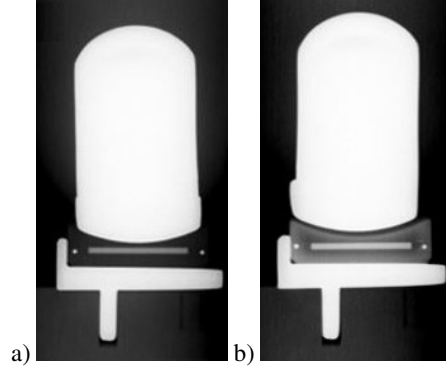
Standard radiographs taken of a) a conventional polyethylene bearing, and b) one which has been treated with Lipiodol, an oil-based contrast agent. The images demonstrate an increased visibility of the polyethylene unicompartmental knee bearings after treatment.
